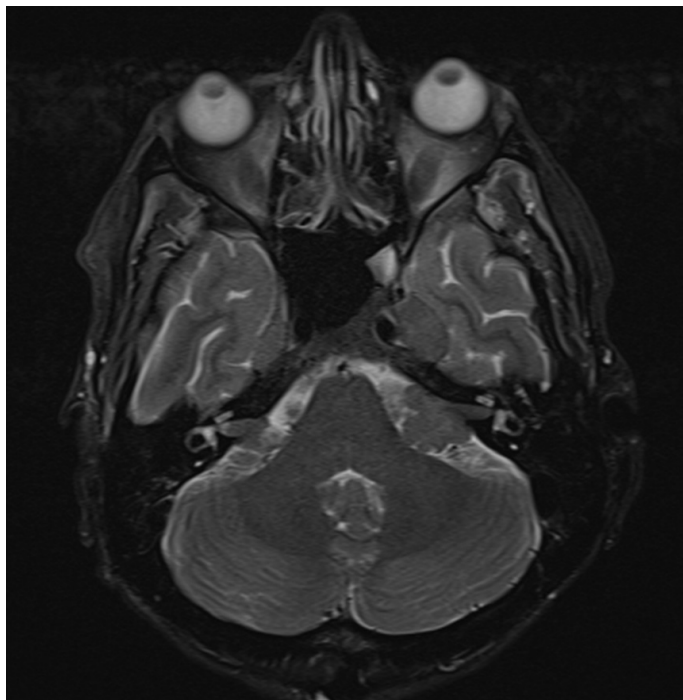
T2-weighted magnetic resonance imaging scan of the brain at the level of the internal auditory canals (IAC). The scan shows bilateral masses in the IAC and cerebellopontine angle (CPA), with left side showing a larger mass.
